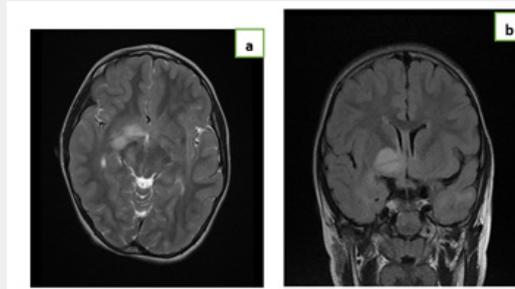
Brain MRI T2 in axial T2(a) and coronal SIGNAL(b) brain MRI showing multiple bilateral diffuse signal abnormalities in T2 and Flair, in unenhanced T1 hypo signal after Gadolinium injection in relation to brain hamartomas returning to NF1.
